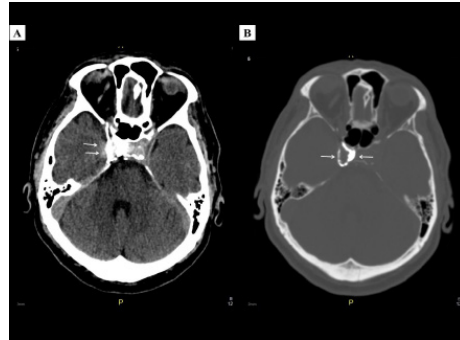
Non-contrast-enhanced computed tomography of the brain in axial images in (A) brain window showing artifact from the right cavernous sinus and in (B) bone window dense embolic material in the right cavernous sinus (Source of Photo: Courtesy of Radiology Department, Hospital of University Malaya).
